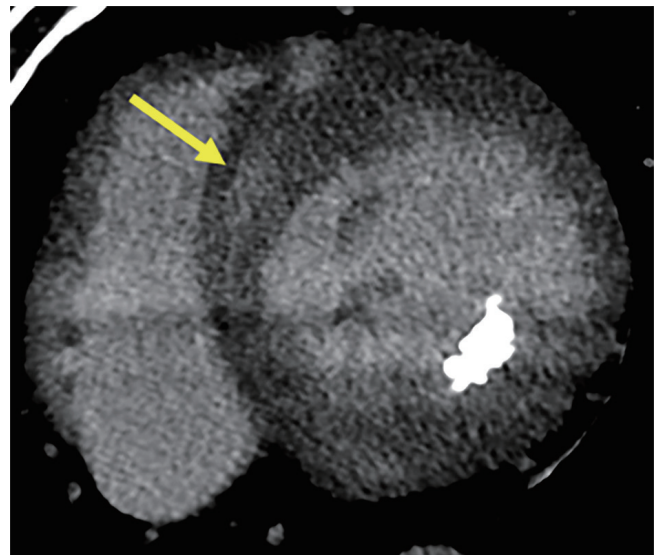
Myocardial assessment. Short-axis 50-keV virtual monoenergetic image from photon-counting CT in a 51-year-old male with hypertrophic cardiomyopathy shows patchy mid-myocardial late iodine enhancement in the basal anteroseptum (arrow).
